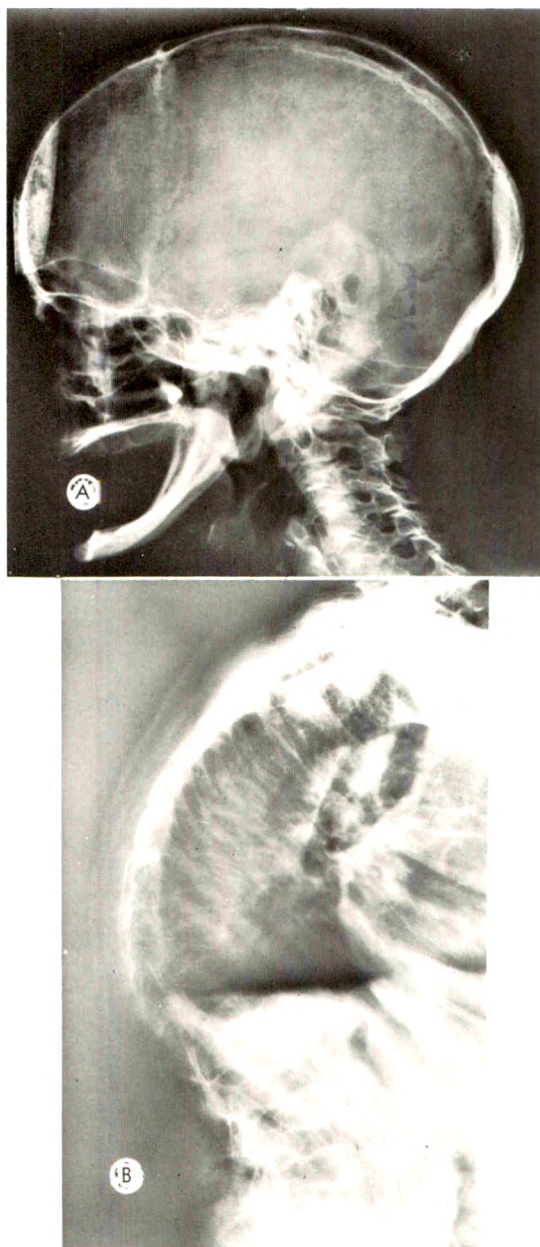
Case I. (A) Skull roentgenogram demonstrates basilar impression. Edentulism is complete except for unerupted maxillary molar. (B) Severe kyphosis and demineralization of spine. The intervertebral disk density is greater than the density of the bodies of the lumbar vertebrae.
